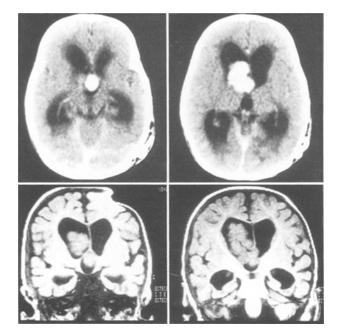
CT Scan and MRI aspect of third ventricle papilloma involving the left ventricle
